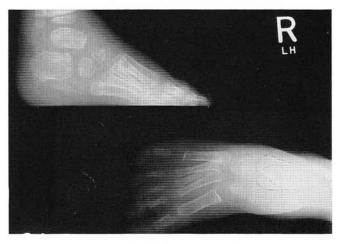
Postoperative radiographs. There is still a moderate amount of metatarsus adductus, but Kites' angle has increased to 24 degrees, there is an increase in calcaneal inclination angle, and heel purchase with the supporting surface is achieved.
